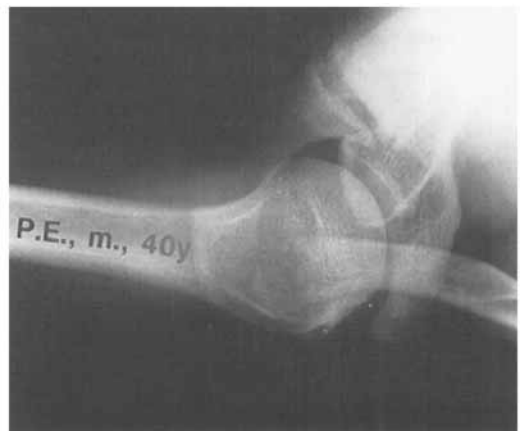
The anteroposterior radiograph with a 30° caudal tilt of the beam and the axial radiograph show pseudarthrosis of the spine of the scapula of a 40-year-old man.
